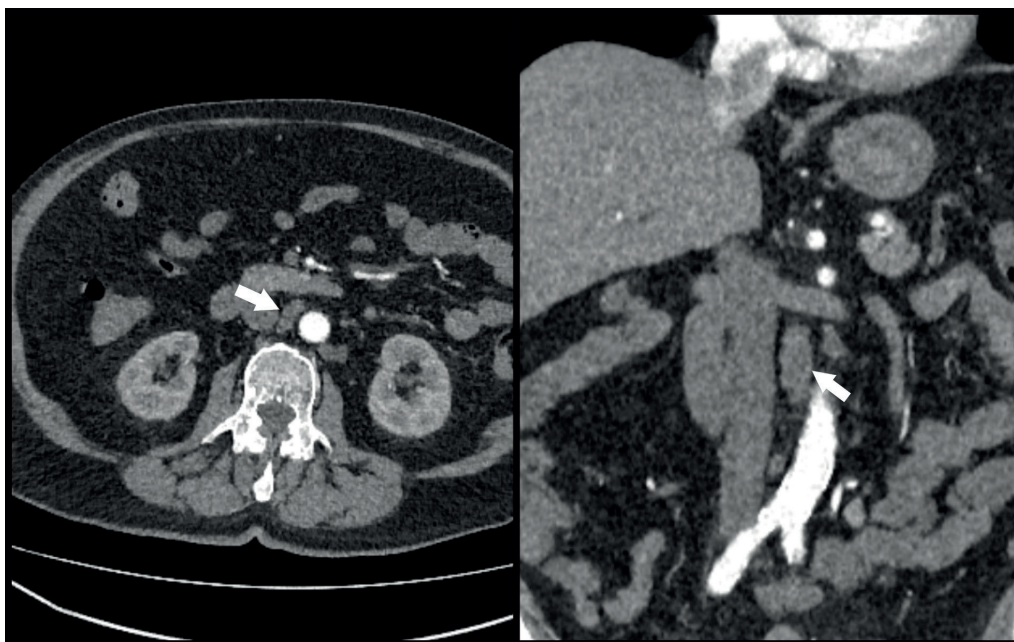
CT image of enlarged retroperitoneal lymph nodes (white arrows)
